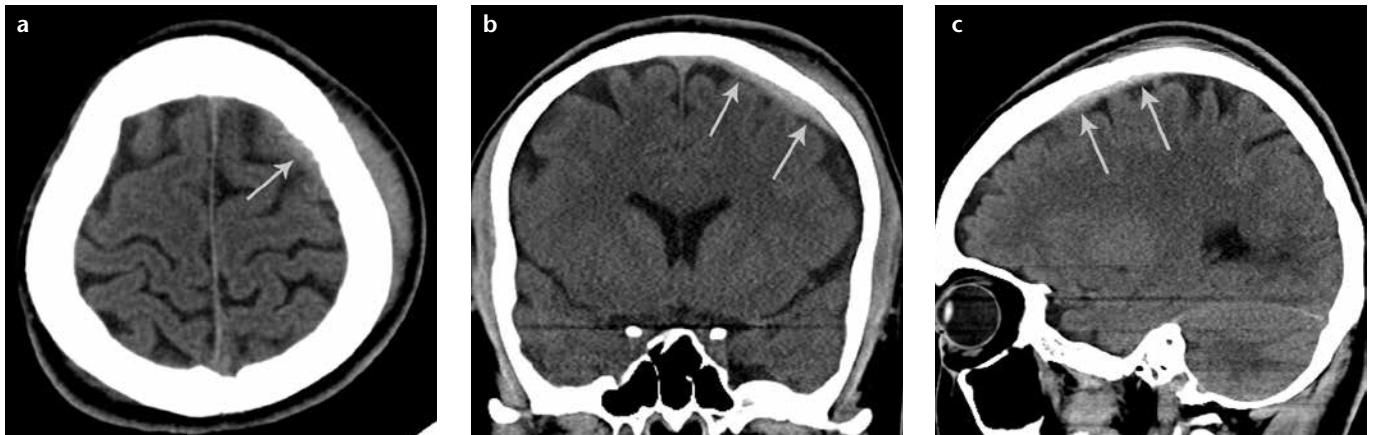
a–c. A 28-year-old female with head trauma. Unenhanced transverse CT image (a) shows a thin left epidural hematoma (*arrow*) that was correctly diagnosed by the neuroradiologist and a radiology resident (missed by two residents). On coronal (b) and sagittal (c) reformatted images, all four readers identified a left epidural hematoma (*arrows*).
